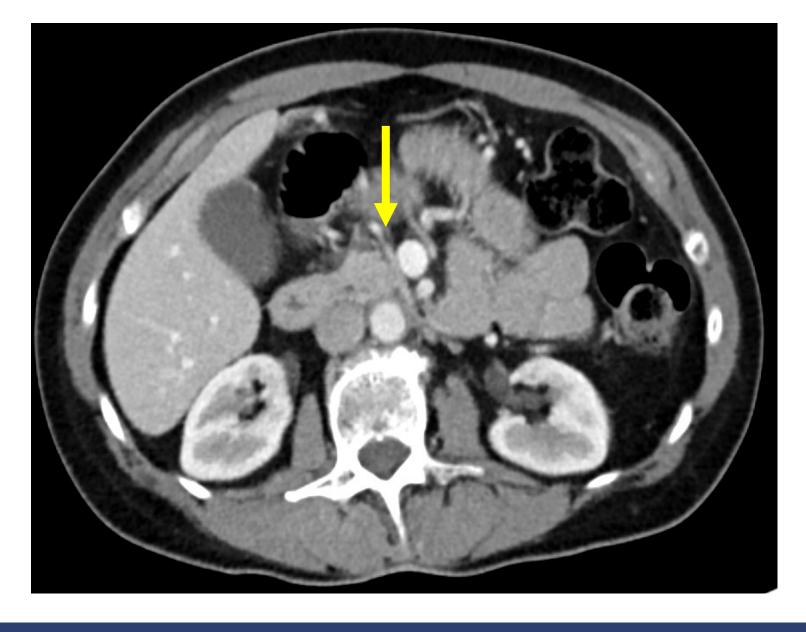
Contrast enhanced coronal (A) and axial (B) CT image shows interval enlargement of the hypo enhancing pancreatic head mass (yellow arrow) with pancreatic duct obstruction with dilatation of the main pancreatic duct.
